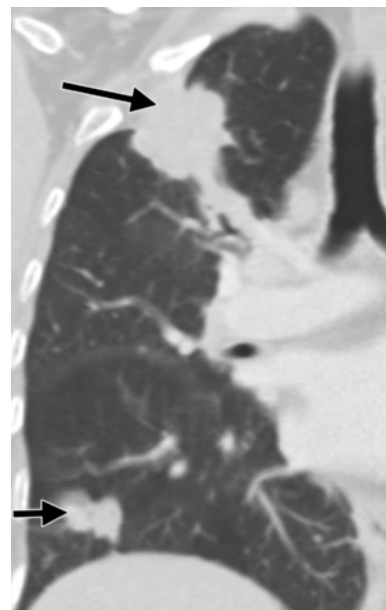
Stage T4 tumors. Chest CT scan shows a primary lung tumor in the right upper lobe (long arrow) with a smaller separate nodule in the right lower lobe (short arrow). In the 7th edition, this is considered stage T4 disease (stage M1 [metastatic] disease in the 6th edition).
